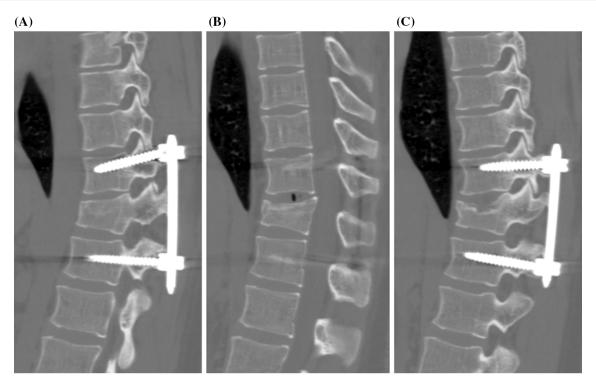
a-c CT MPR sagittal reconstructions. L2 traumatic collapse treated by posterior stabilization with bars and transpedicular screws at L1 and L3, correctly positioned
